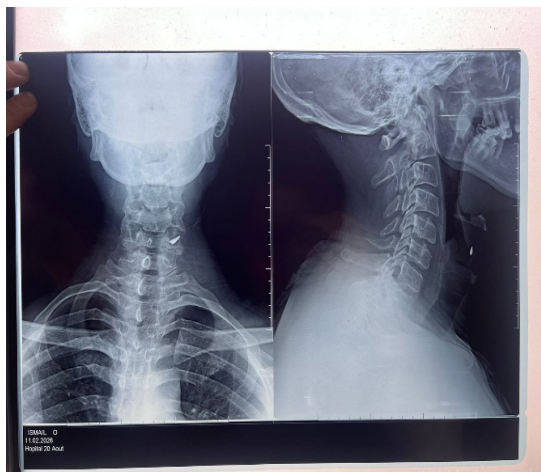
Plain anteroposterior cervical radiograph demonstrating an approximately 8-mm radiopaque metallic foreign body embedded within the left sternocleidomastoid muscle (arrow)
